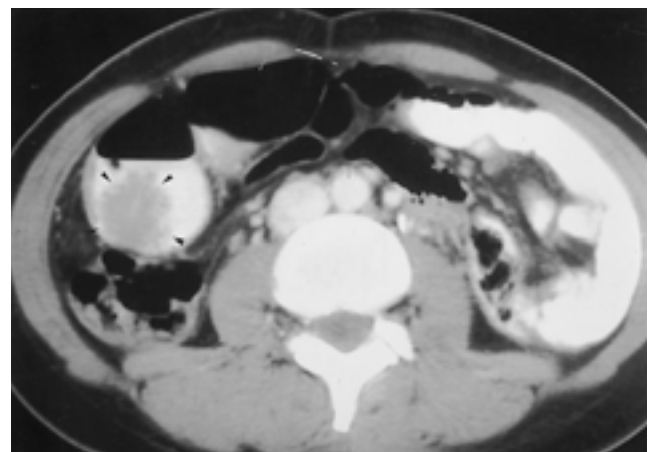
Preoperative CT scan shows a irregular polypoid mass (arrow-head) in the ascending colon. This polypoid mass was confirmed to tubovillous adenoma.
